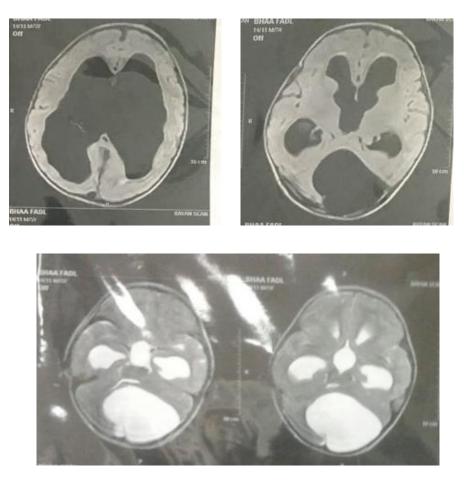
MRI Show Hydrocephalus with retro cerebellar cyst
